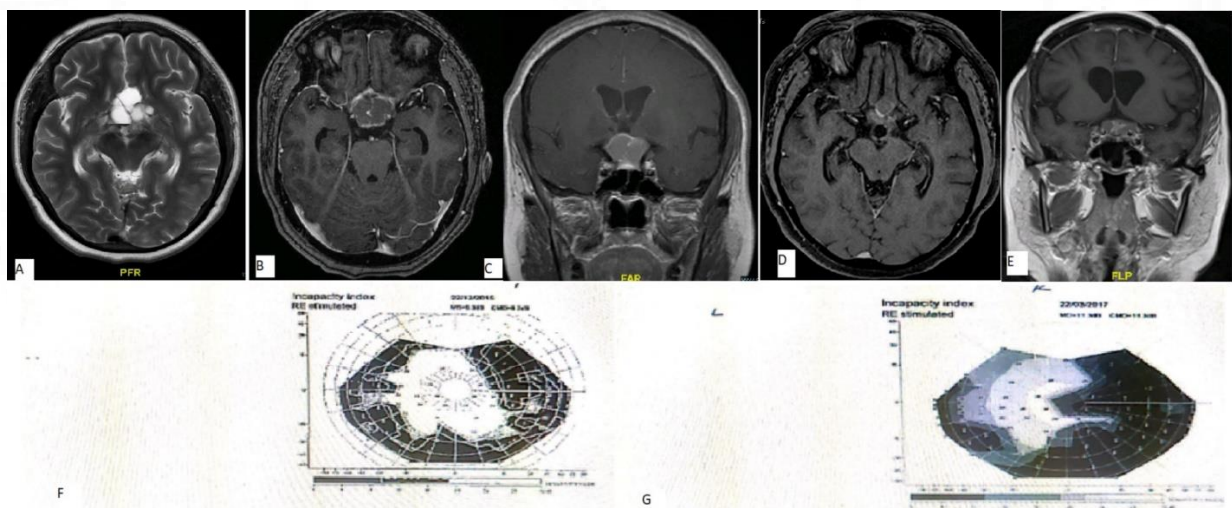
Preoperative and postoperative MRI of brain and visual field testing. A- T2 axial MRI showing solid cystic lesion in suprasellar area. B- Axial T1 contrast showing enhancing lesion in suprasellar region. C- Coronal T1 contrast showing the same. D- Post operative axial T1 contrast MRI showing residual lesion in suprasellar area. E- post operative contrast MRI showing the same.
